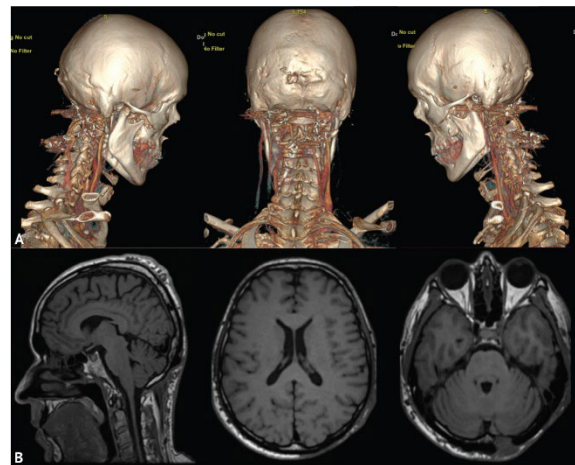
Control studies 6 months after surgery. A – 3D reconstruction of CT angiograms; B - magnetic resonance imaging of the brain
